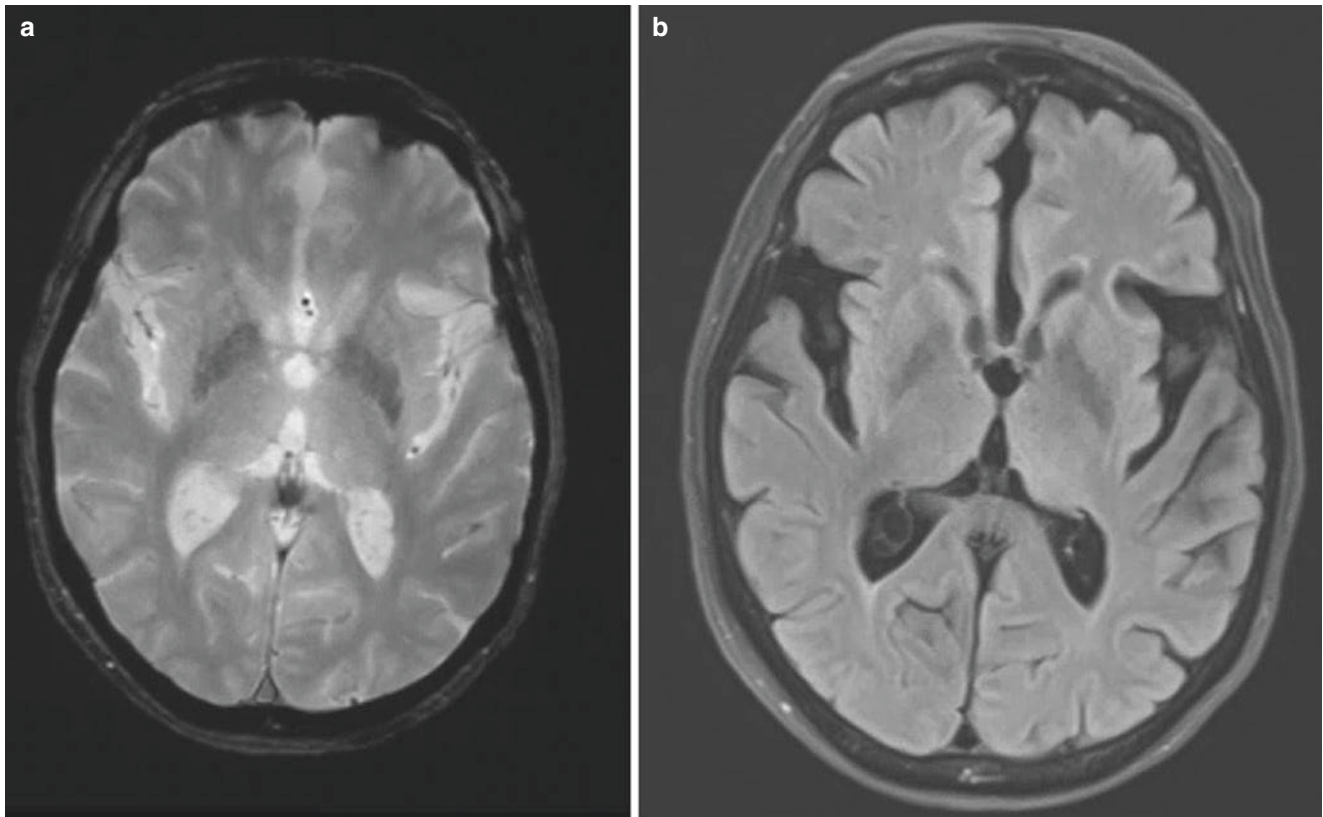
MRI T2 GRE (a) and T2-FLAIR (b) demonstrate signal changes that include a hypointensity of the posterior putamen and hyperintense lateral putaminal rim
